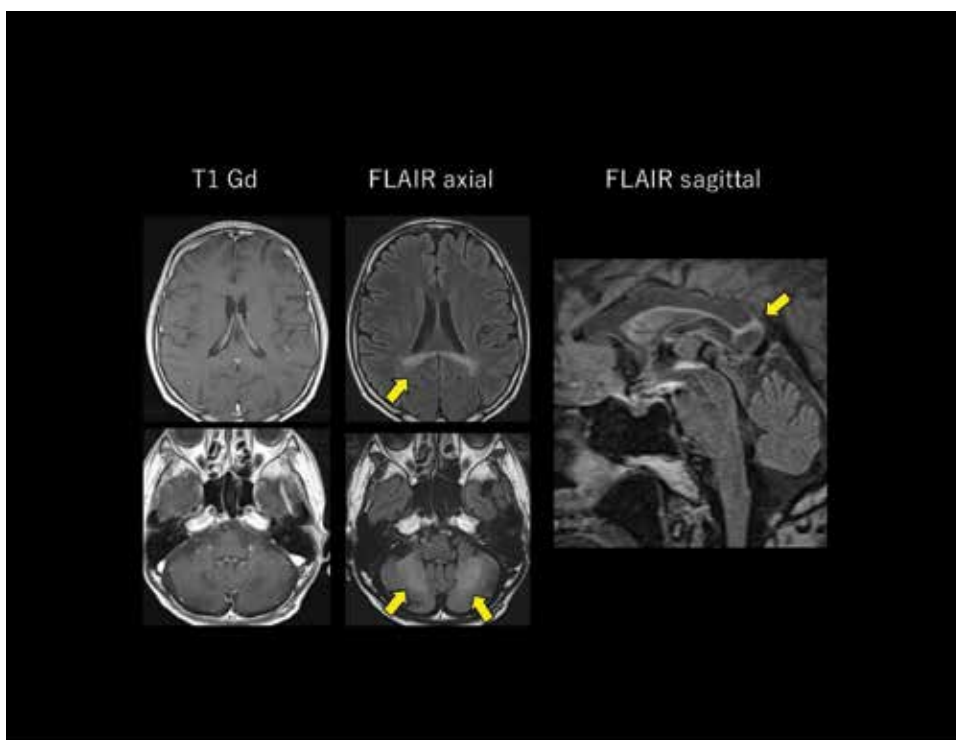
Brain MRI of the adrenoleukodystrophy patient. T1 gadolinium (Gd) enhance: no enhanced area in his brain. FLAIR axial: FLAIR hyperintensities in the cerebellar white matters and callosal body (arrow). FLAIR sagittal: FLAIR hyperintensities in the callosal body (arrow).
